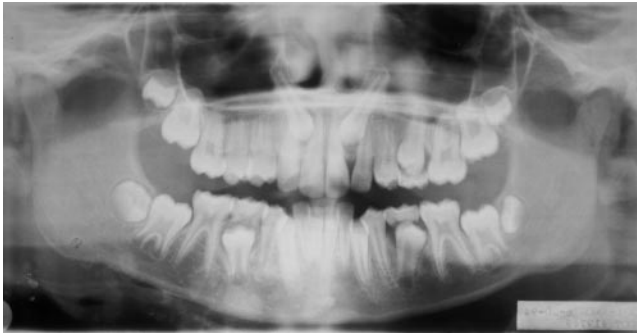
Pretreatment panorex radiograph.
